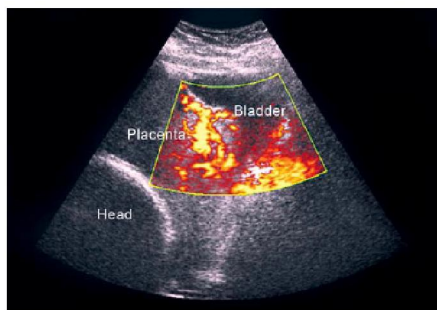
Spectral power Doppler Ultrasound image of vessels exhibiting high velocity and low impedance flow
